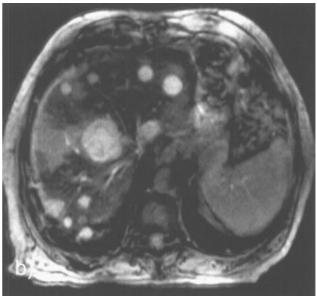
Liver MR images. Metastases of a gall bladder carcinoma. Left: shortly after the application of Resovist®; dynamic phase T_1 -weighted two-dimensional FLASH image. Right: accumulation phase, T_2 -weighted two-dimensional FLASH. 10 μmol of iron per kilogram body weight. A number of metastases are clearly seen, especially in the T_2 -weighted image. For details see Reimer and Tombach. Occurrence of Dr B. Tombach, Department of Radiology, University Hospital Münster, Germany).
